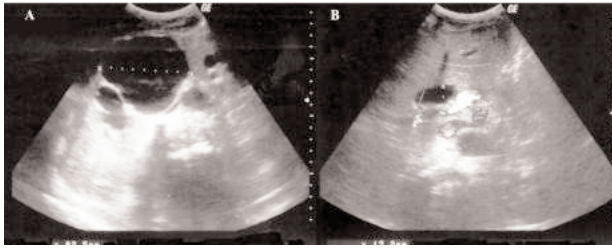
Abdominal ultrasonography showing the crossed, fused renal ectopia with right renal hydronephrosis, and a dishomogeneous renal cyst of 92 mm causing compression and dilatation (17 mm) of the choledochus.
